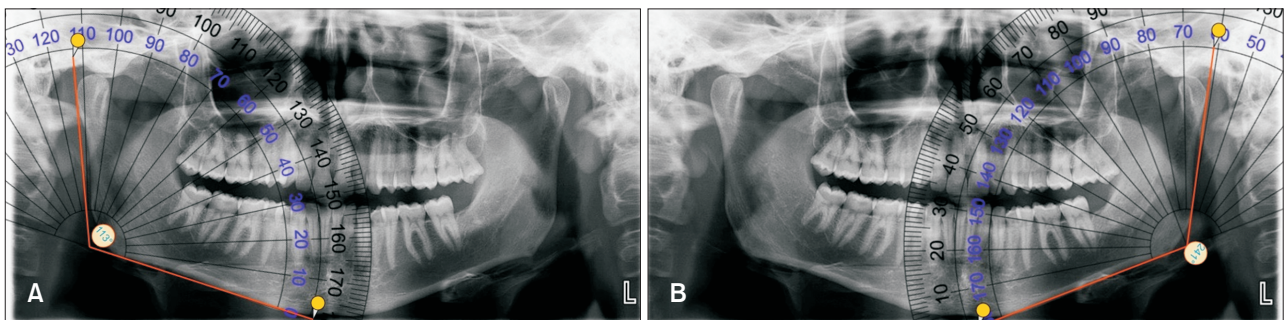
Gonial angle measurement. The angle between the tangent to the posterior edge of the ramus mandible and the tangent to the lower edge of the corpus mandible is measured on the right (A) and left (B) sides on panoramic radiography.
